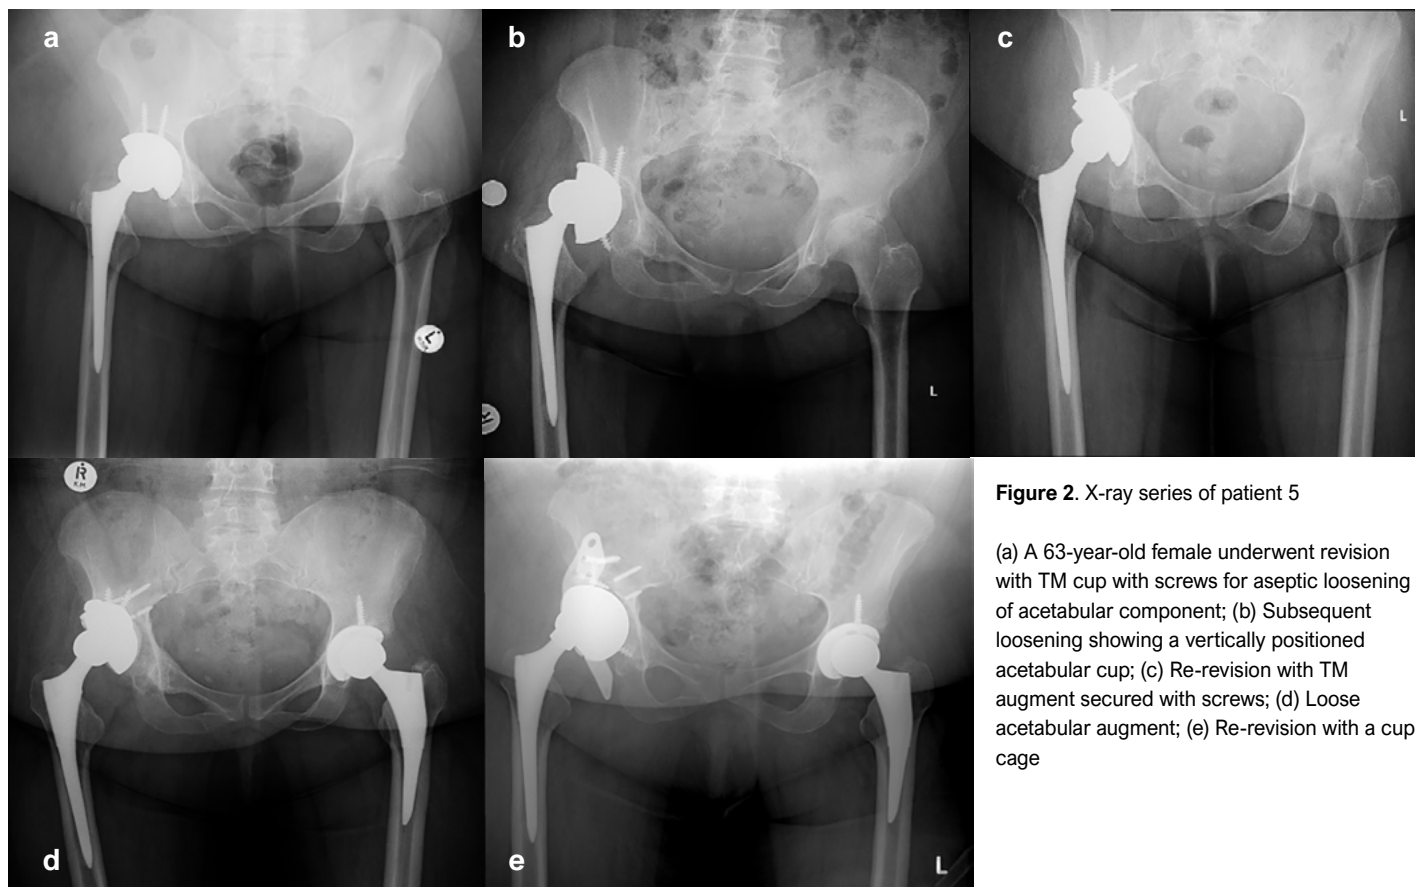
X-ray series of patient 5
